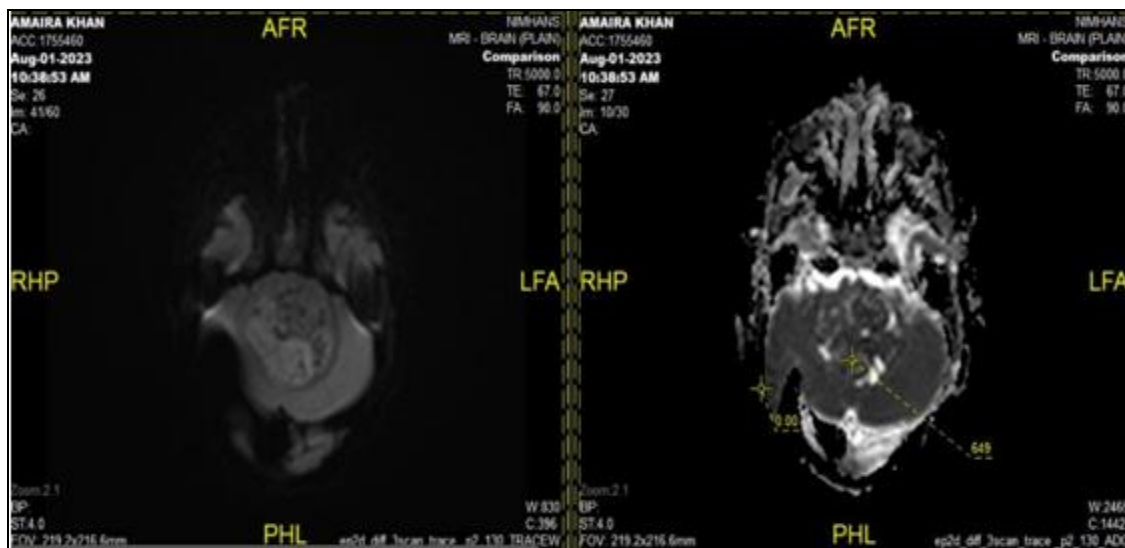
ADC AND DWI IMAGES IN A CASE OF PYOGENIC BRAIN ABSCESS SHOWING TRUE DIFFUSION RESTRICTION WITH LOW SIGNAL ON ADC. THERE IS A SIGNIFICANT PERI LESIONAL EDEMA.
